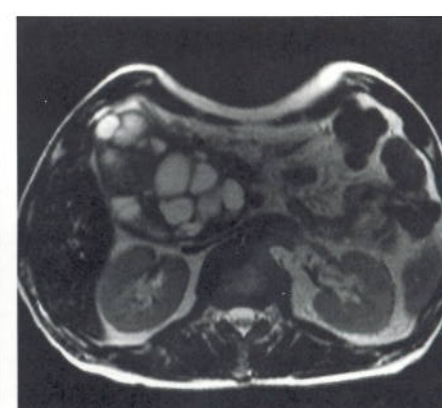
TSE 65 echo train technique for breathhold T2-weighted abdomens.
